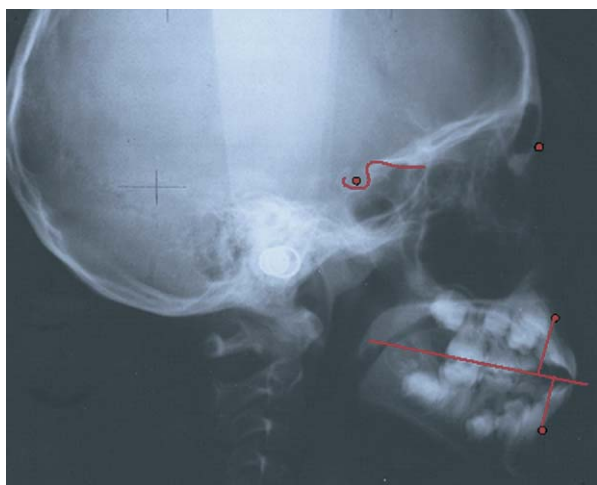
Horizontal growth changes of maxilla and mandible between posttreatment radiograph and follow-up radiograph were determined by locating A-point and B-point on first radiograph. Occlusal plane (O) constructed by using mesiobuccal cusp of maxillary molars and incisal tip of maxillary incisors as landmarks. Lines AO and BO were then constructed by connecting Points A and B perpendicular to occlusal plane.
